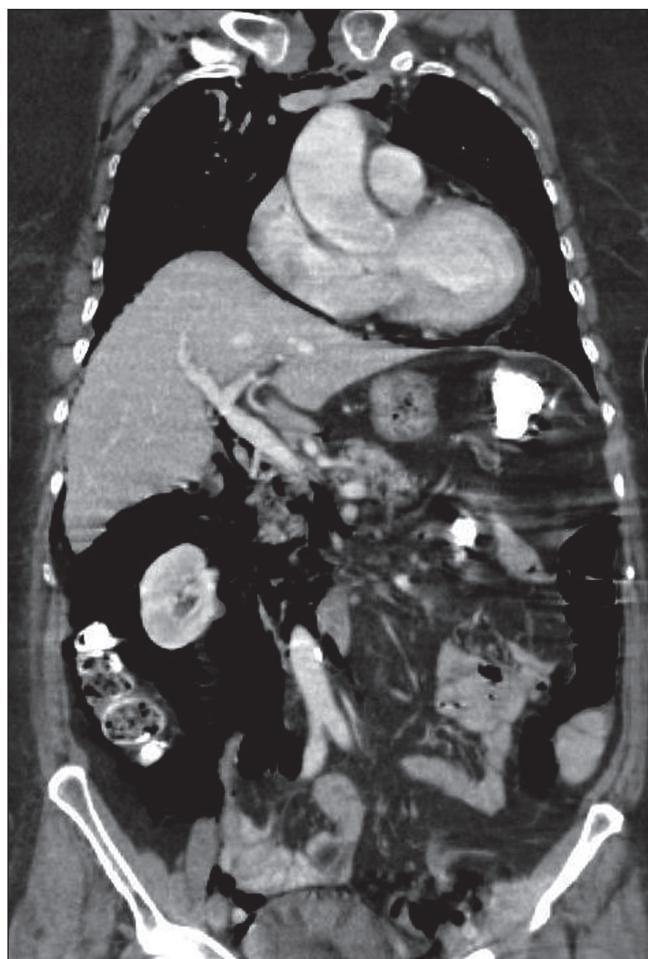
CT scan showing a large amount of ectopic air in the retroperitoneum. Due to hiatal hernia presence, air was seen also in the mediastinum, neck and head.
